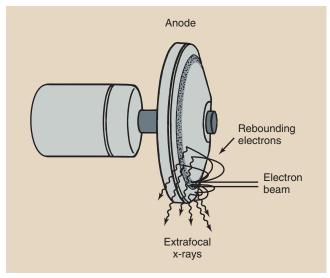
Extrafocal x-rays result from interaction of electrons with the anode off of the focal spot.
